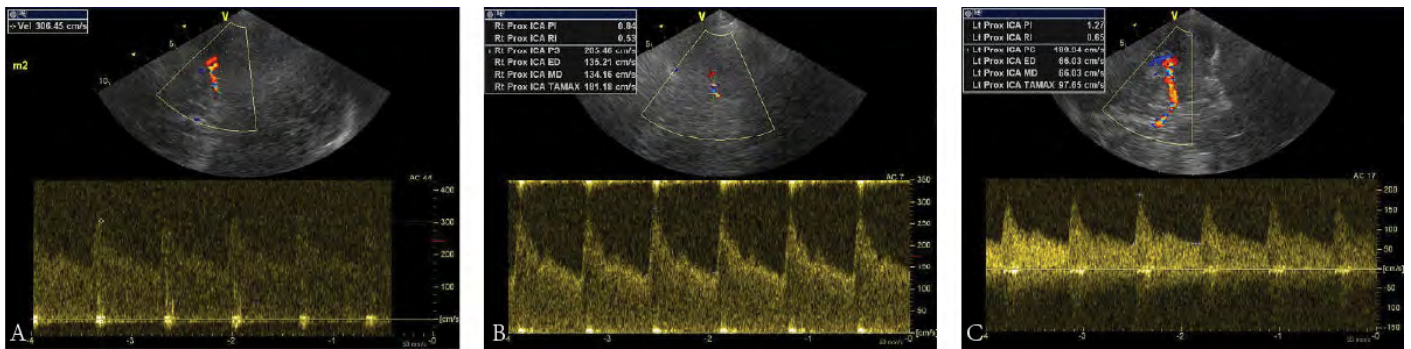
The Color Doppler sonography of vessels demonstrated severe stenosis in the M1 segment of the right middle cerebral artery (A) and the terminal segment of the right internal carotid artery (B), and moderate stenosis of left anterior cerebral artery (C).
